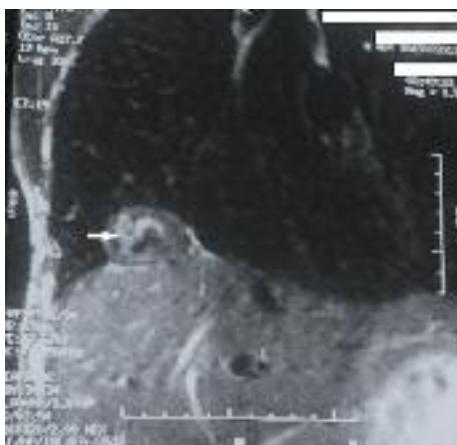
Coronal T1-weighted magnetic resonance image showing hypointense heterogeneous mass with central calcifications, independent of the diaphragm (white arrow).
